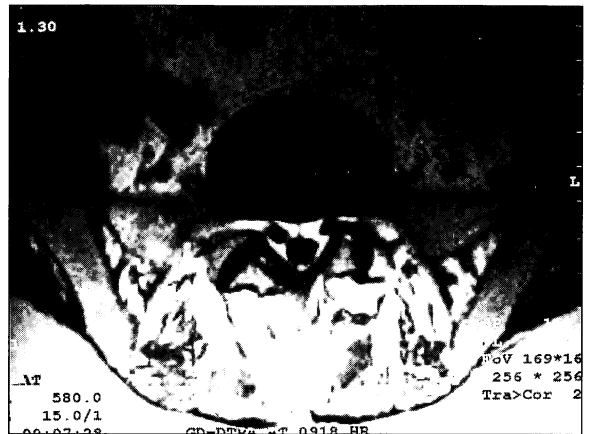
Axial T1-weighted scan showing narrowing of the left lateral recess. Note the facet hypertrophy and impingement of the adjacent nerve root
